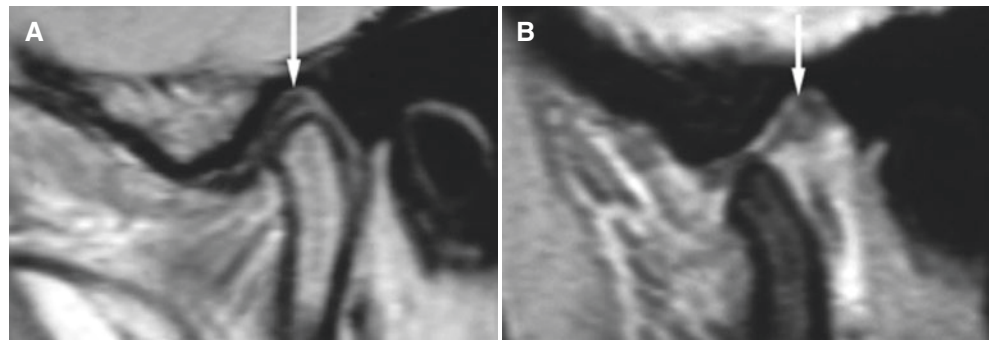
Stuck (fixed) disc, normal bone. (A) Oblique sagittal MRI shows the disc (*arrow*) in normal position. (B) Oblique sagittal open-mouth MRI shows the disc (*arrow*) in the same position, no motion of the disc with the condyle, probably due to fibrous adhesions
